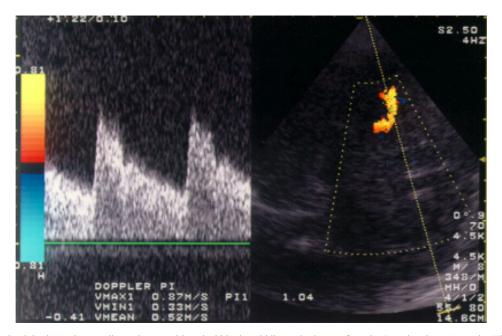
The image on the right shows the sampling volume positioned within the middle cerebral artery for color Doppler ultrasonography. That on the left shows the time-velocity waveform.
